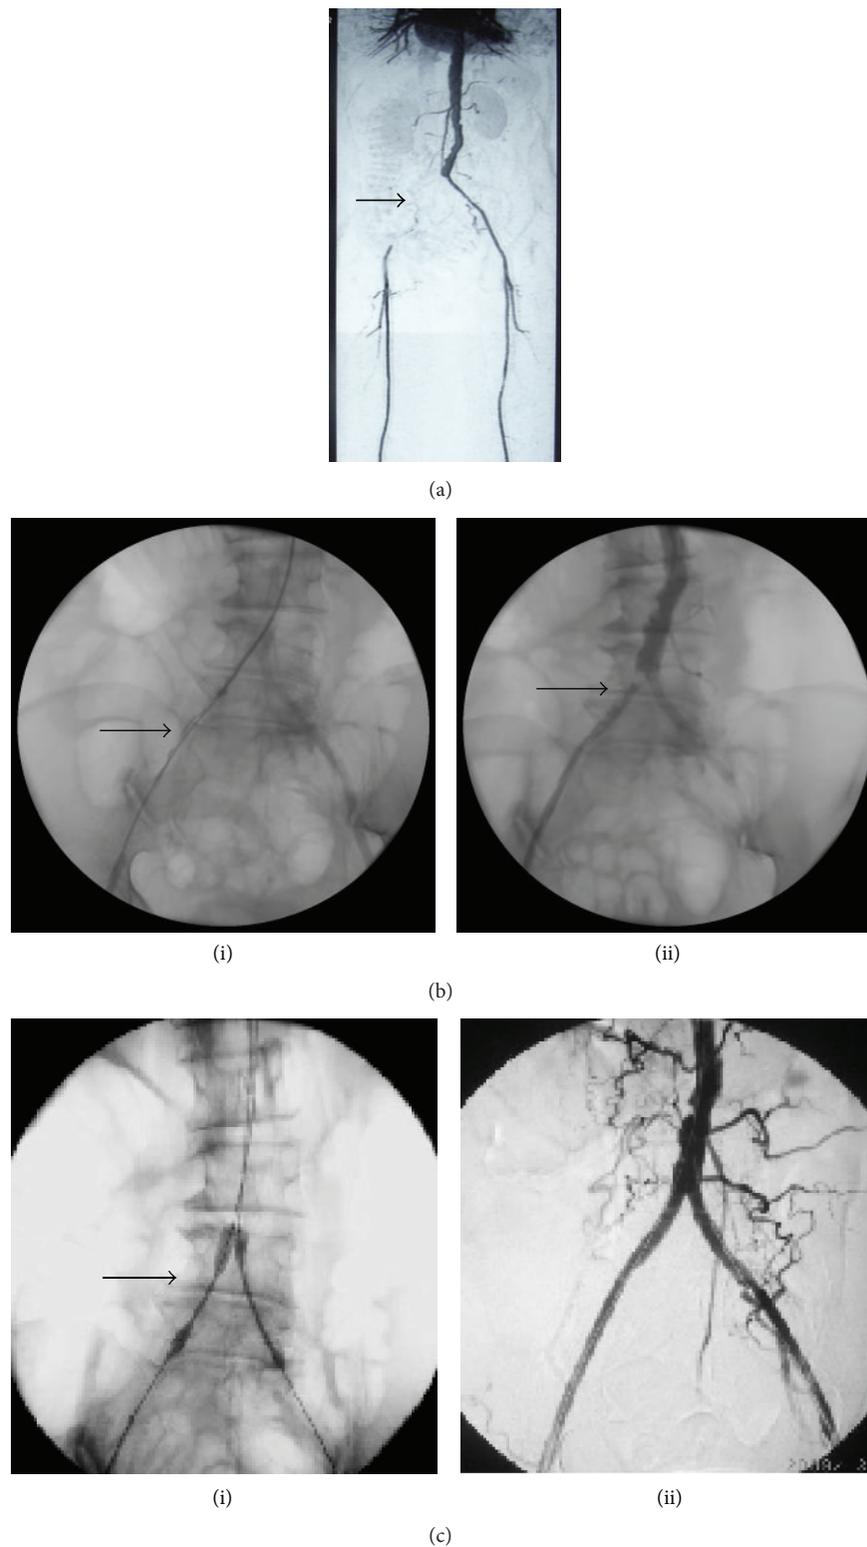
Case (1): stenting for a female PAD patient of 69 years. (a) CTA showed severe right iliac artery occlusive lesions about 12 cm (arrow). (b) (i) Thrombolysis by catheter (arrow). (b) (ii) Two days later, angiogram showed right iliac artery occlusive lesion changed from TASC II D to B (arrows). (c) (i) Endovascular angioplasty by Kissing-stenting (arrow). (c) (ii) Excellent result at right iliac artery.
